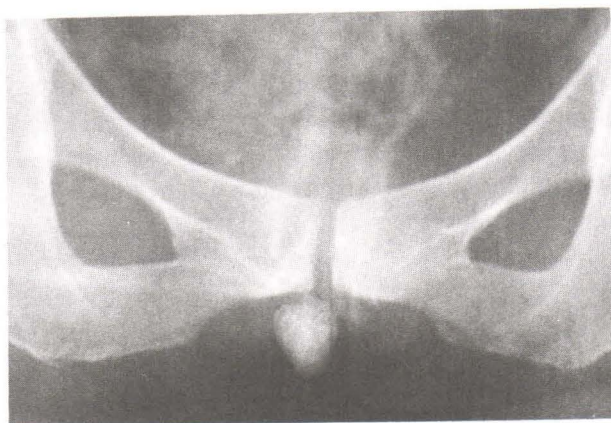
Plain film shows a stone in the urethral diverticulum. (AP film)
